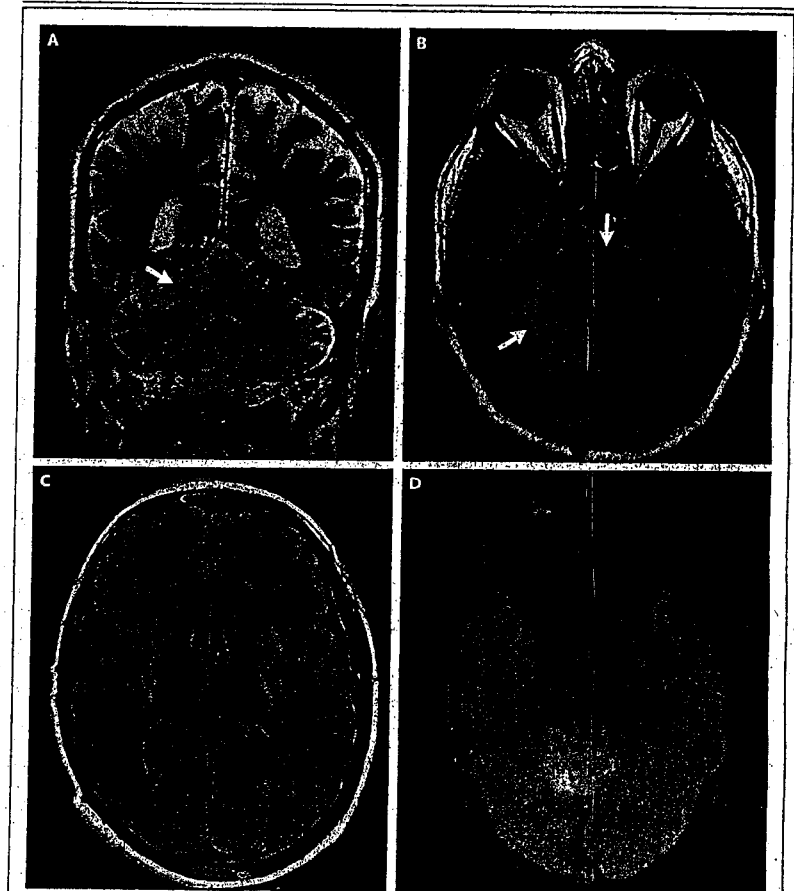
Magnetic Resonance Imaging (MRI) of the Brain on Hospital Admission.
